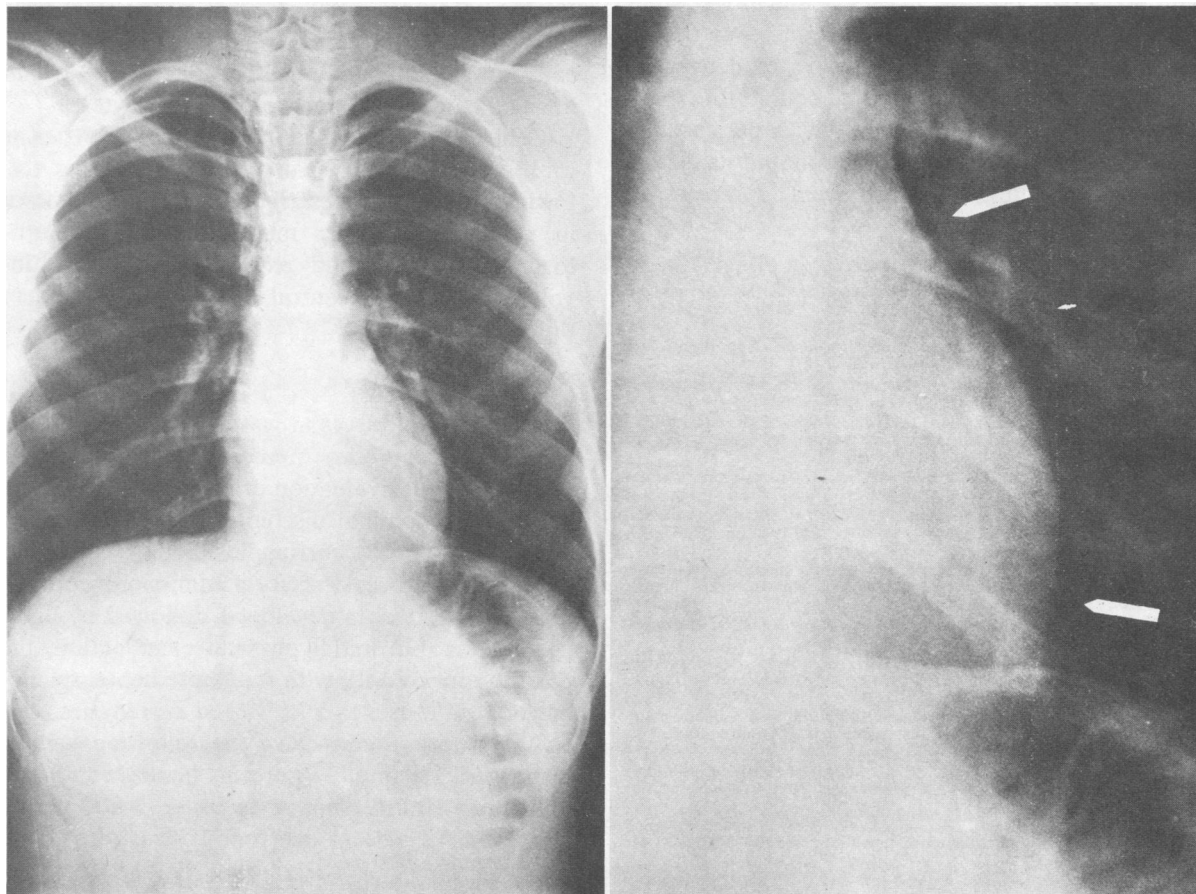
Left, posteroanterior roentgenogram of the chest showing a radiolucent space along the left heart border surrounded by and defining a thin pericardial membrane. Right, enlargement showing the pericardial membrane (arrows).
